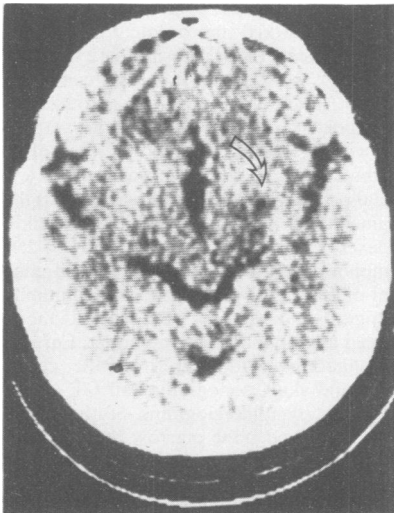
Fig Unenhanced CT scan (performed 25 days after onset): low density area in the lateral part of the left lenticular nucleus (arrow).
